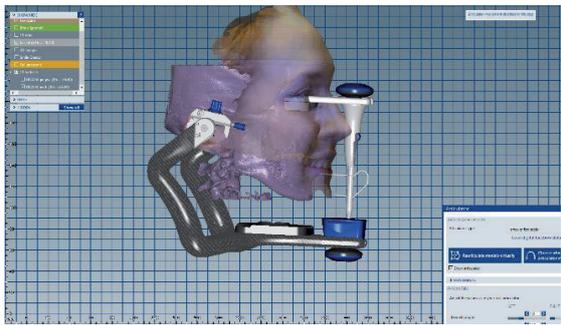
CBCT scan, face scan, bite fork scan and dental arch scans uploaded into the Virtual Artex CR digital articulator (Amann Girrbach, Germany)
